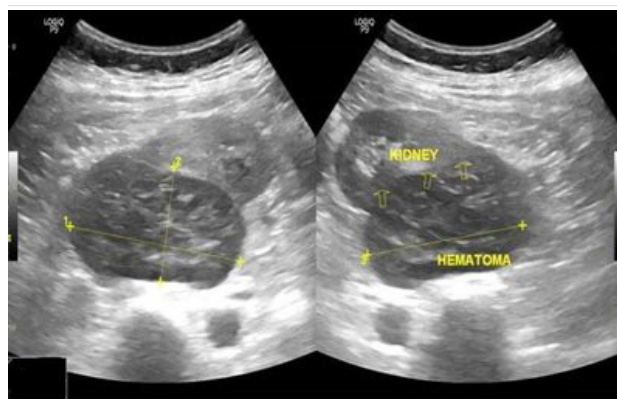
Ultrasound pictures showing the right kidney with perirenal hematoma (106mm x 61mm x 71mm).
